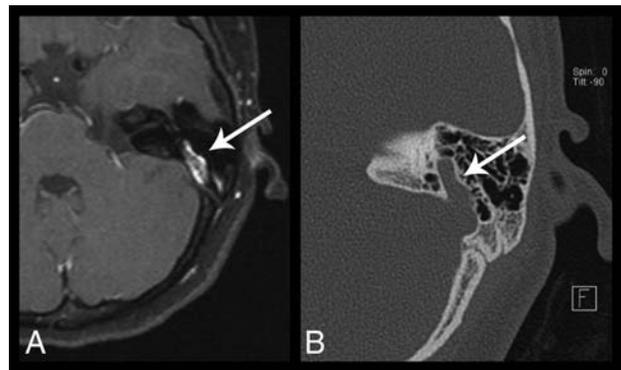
Axial postcontrast fat-saturated T1-weighted image (A) and axial temporal bone CT image (B) of the left temporal bone demonstrate a prominent left transmastoid emissary vein (arrows).
